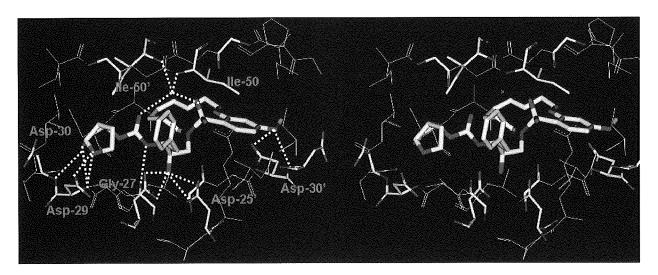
A stereoview of the X-ray structure of macrocyclic inhibitor 14c (light gray)-bound HIV-1 protease. All strong hydrogen bonding interactions are shown as dotted lines.
